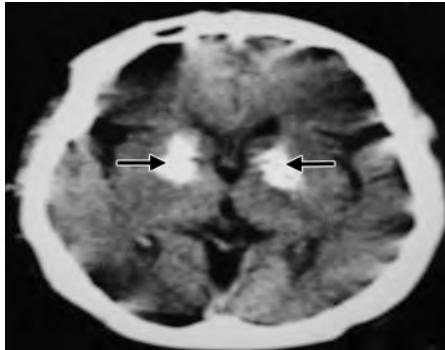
Basal ganglia calcification. An axial noncontrast CT head scan demonstrating calcifications in the bilateral basal ganglia (indicated by black arrows)
